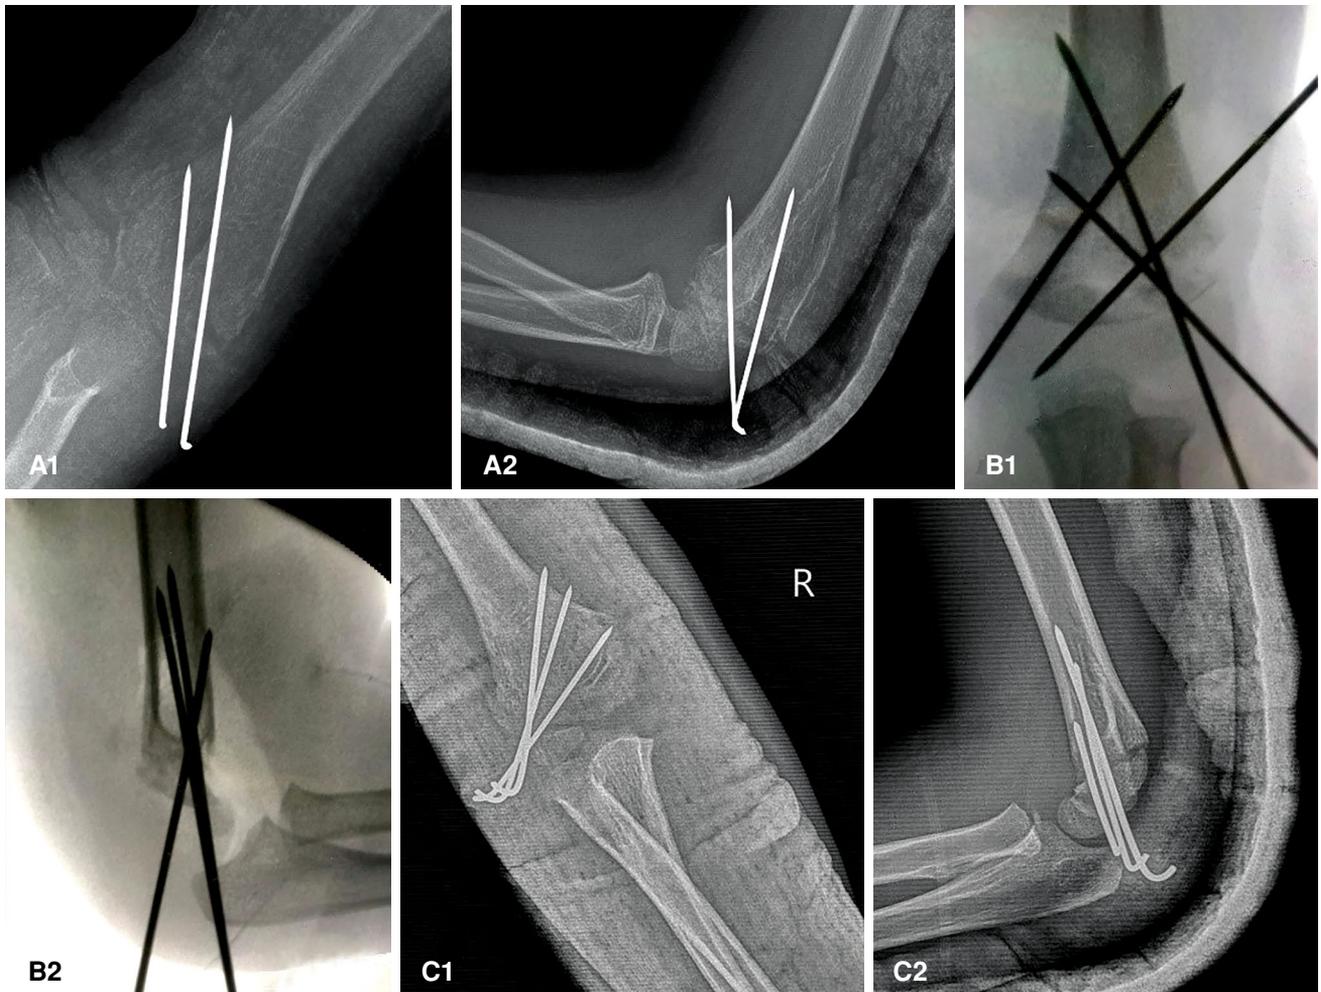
Postoperative (A1) anteroposterior and (A2) lateral radiographs of Patient 1. (B1 and B2) Postoperative fluoroscopic images of Patient 2. Postoperative (C1) anteroposterior and (C2) lateral radiographs of Patient 4.
